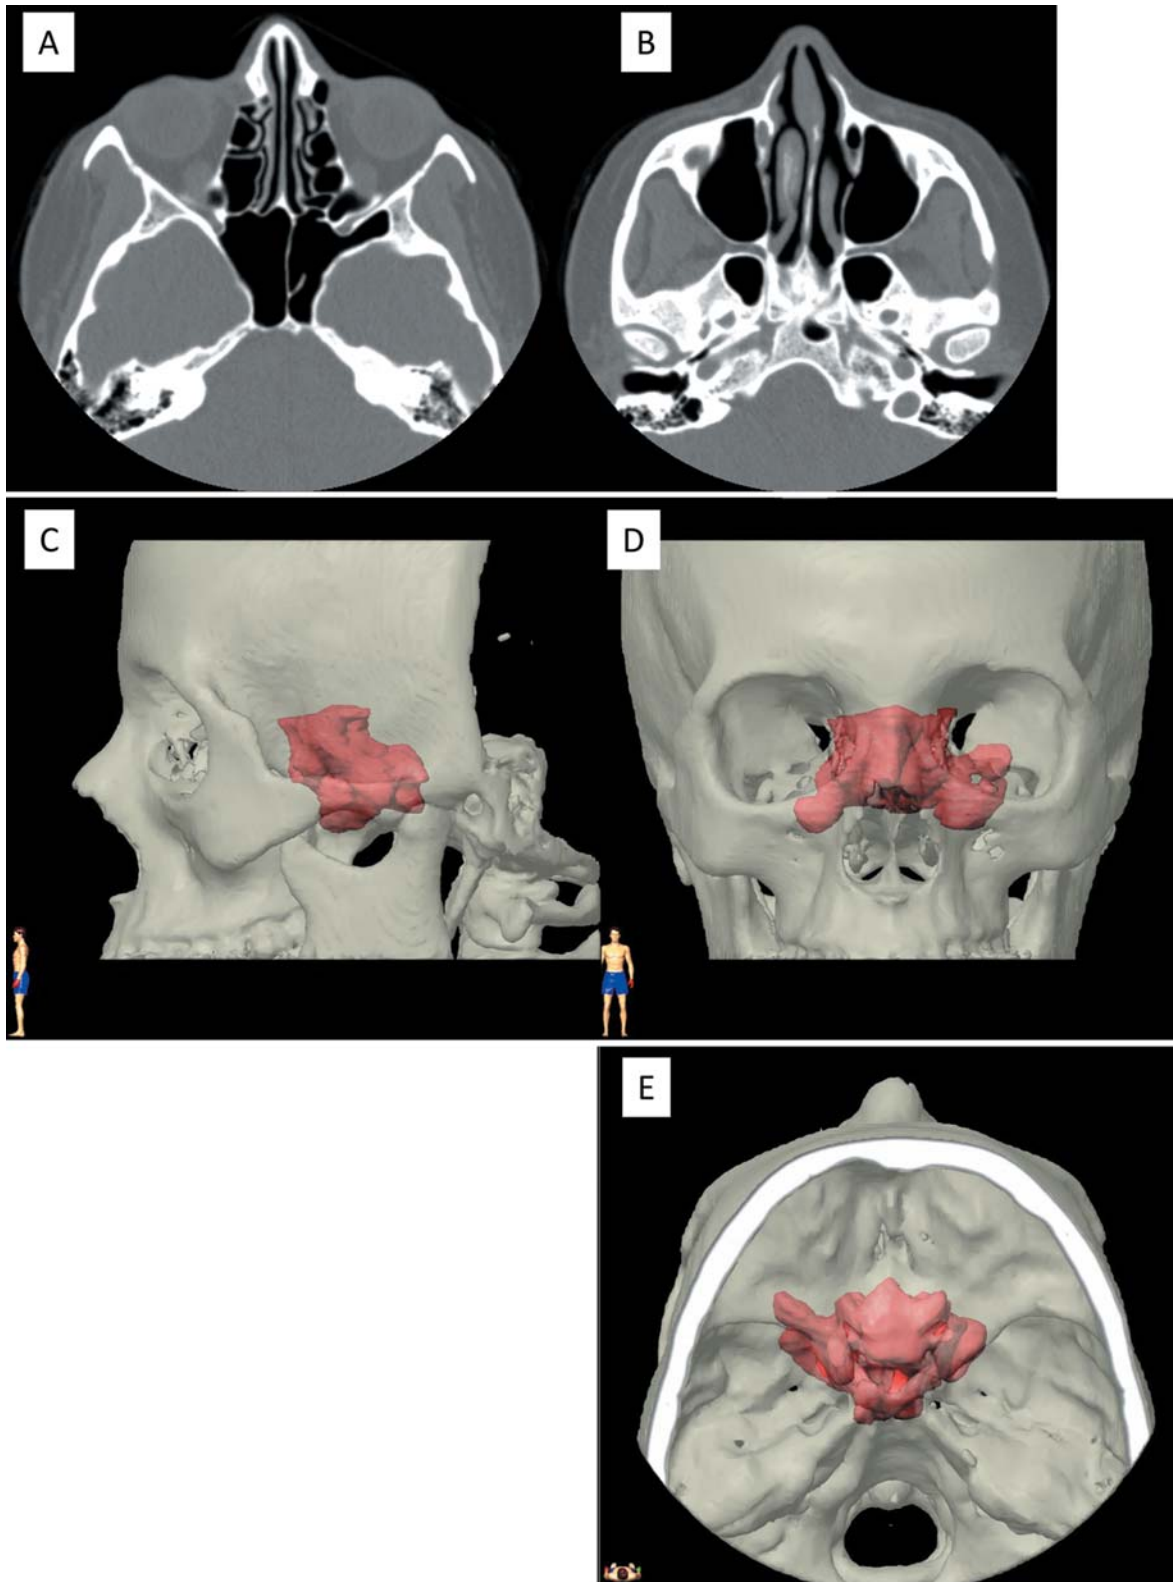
Selected images of enlarged sphenoid sinus derived from computed tomographic (CT) scans. The axial CT slices show aeration of the left greater wing of the sphenoid bone (A) and the pterygoid process on both sides and clivus (B). Volume reconstruction with BrainLab®-software: lateral view (C), anterior view (D) and cranial view (E).
